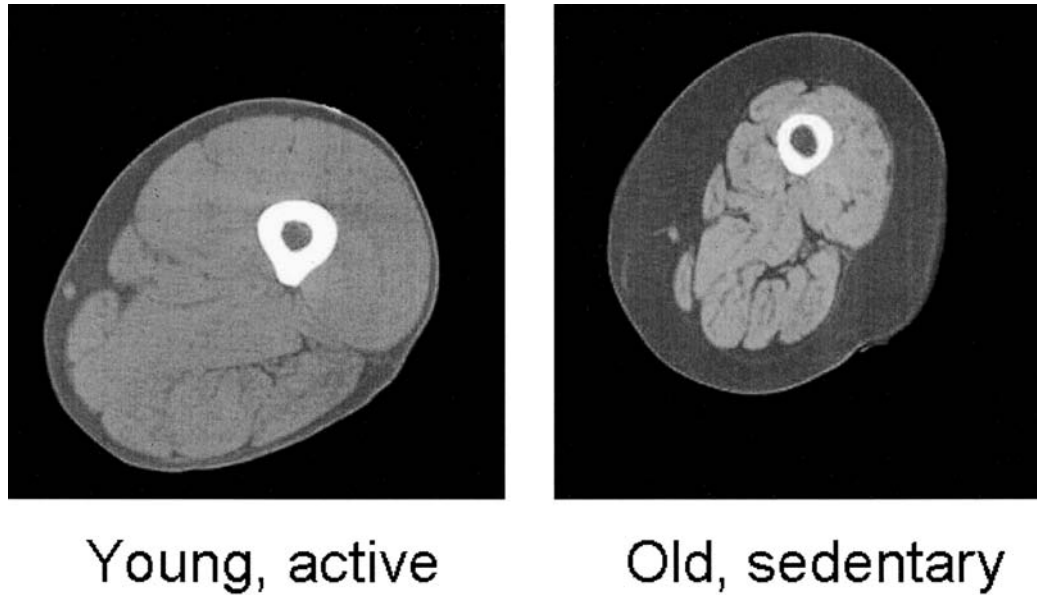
Sarcopenia. Magnetic resonance images through the midthigh of a 25-year-old healthy adult (left) and a 75-year-old healthy adult (right) demonstrating sarcopenia. Note the smaller muscle mass (light gray), larger subcutaneous fat (dark gray), and increased intramuscular fat (dark gray lines) in the older participant's leg.
